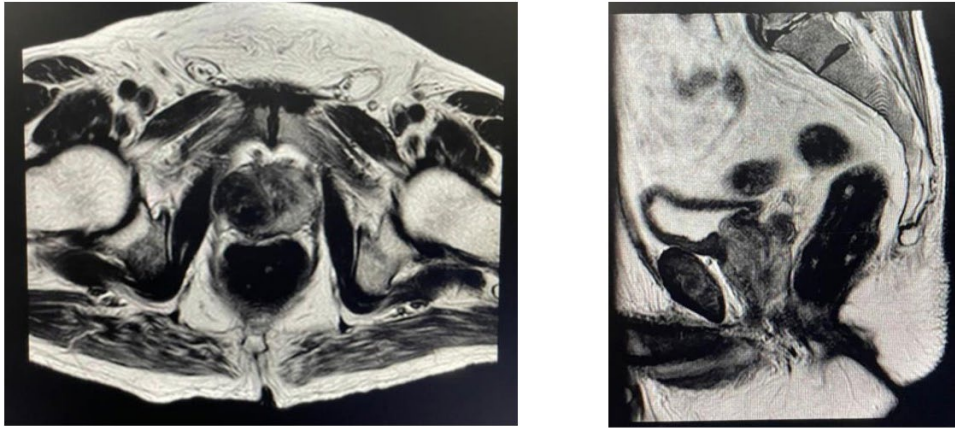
Magnetic resonance imaging of the prostate revealing heterogeneous mass with diffusion restriction and early enhancement measuring $3.2 \times 3.3 \times 5.8$ cm replacing the peripheral zone of the prostate, infiltrating the right neurovascular bundle, base, and right side of the seminal vesicle with the abutment of the right obturator internus muscle on the lateral side.
